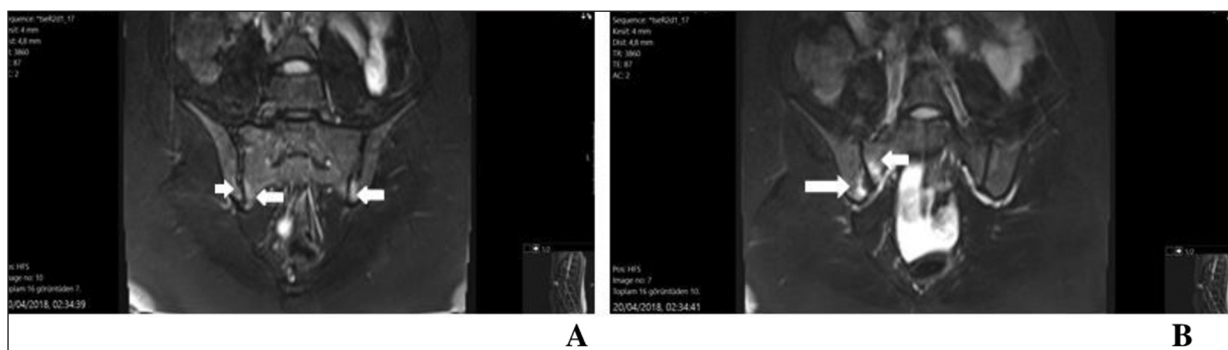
Increased signal intensity and bone marrow edema in the inferior portion of bilateral sacroiliac joint, prominent on the right side (water-only T2-weighted Dixon image, oblique-coronal planes).
